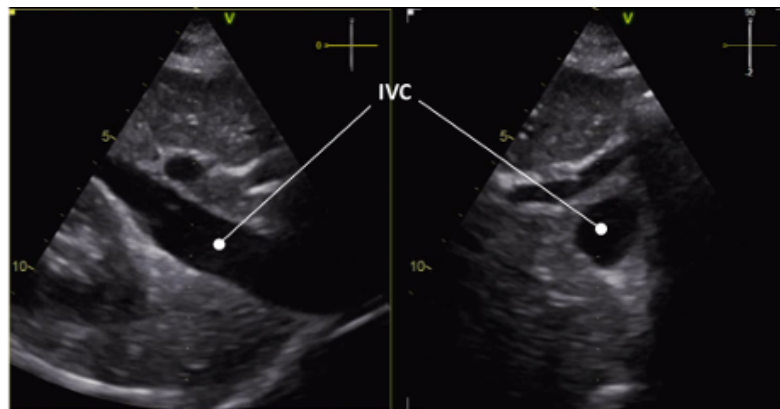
B-mode ultrasound views of the IVC: longitudinal section (left); transverse section (right).[5]
